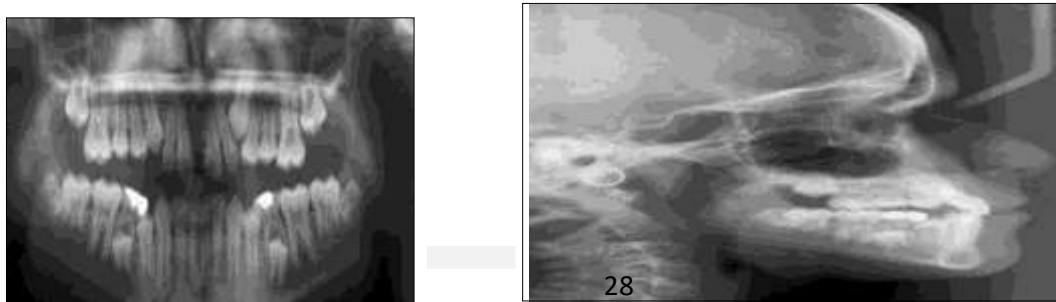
Post-treatment radiographs. (a) Panoramic. (b) Lateral cephalometric radiograph.
